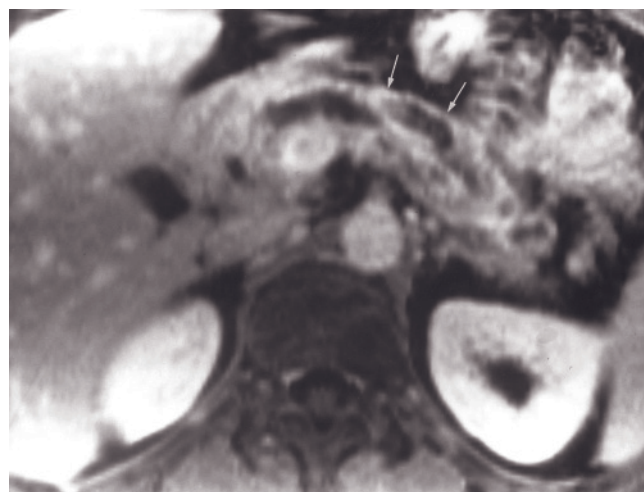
Chronic pancreatitis with moderate to severe pancreatic duct dilatation. T2-weighted SS-ETSE (*a*), T1-weighted fat-suppressed SGE (*b*), immediate postgadolinium T1-weighted SGE (*c*), and 90-s postgadolinium fat-suppressed SGE (*d*) images in a patient with hereditary pancreatitis and recurrent bouts of pancreatitis. The pancreatic duct is very dilated (arrows, *a*). The pancreatic parenchyma is atrophic and is low signal on noncontrast T1-weighted fat-suppressed SGE (*b*). The thin rim of atrophic pancreas enhances minimally on immediate postgadolinium image (*c*) and shows late enhancement (arrows, *d*) consistent with changes of fibrosis. The pancreas is atrophic for the patient's age (18 years old), and it shows heterogeneous signal intensity on T1-weighted images (*b*) with diminished enhancement on postgadolinium images (*d*). The pancreatic duct is severely dilated.
